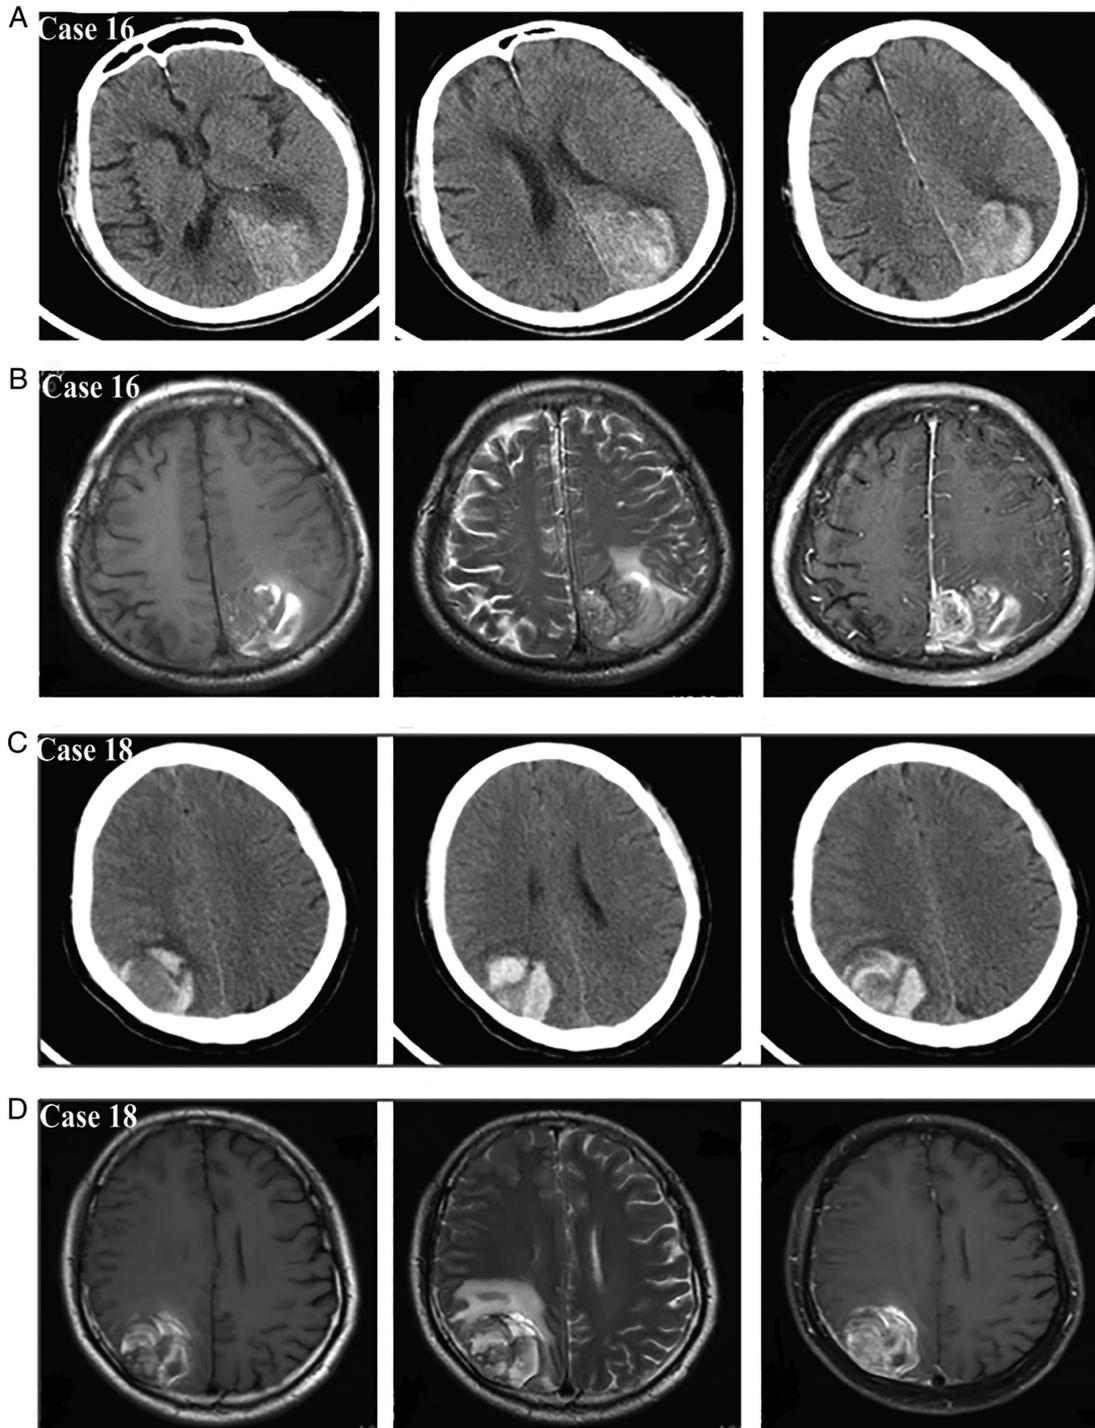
Neuroimaging outcomes of (A and B) representative case 18 and (C and D) case 16 with combined intra/extratranscortical hemorrhage. Brain computed tomography displaying (A) an extra-brain mass lesion in the left parasagittal region of case 16 and (C) an extra-brain mass lesion in the right parietal-occipital area of case 18, which displaced the adjacent brain and had acute bleeding involving intratumoral hemorrhage, peritumoral hematoma, subarachnoid hemorrhage and subdural hemorrhage. Magnetic resonance imaging further showing (B) an extra-brain mass lesion in the left parasagittal region of case 16 and (D) an extra-brain mass lesion in the right parietal-occipital area of case 18, which were heterogeneously enhanced, and significant brain edema was visible in the adjacent brain parenchyma.
